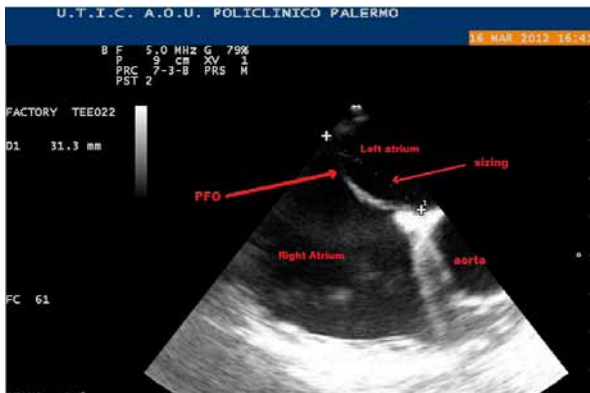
Sizing of the PFO (Transesophageal Echocardiography).
